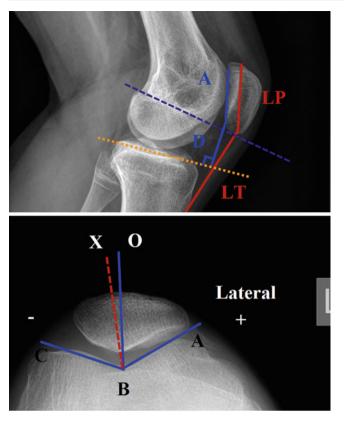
Radiological indices around the knee. Top radiograph (*knee lateral*) shows the Blumensaat's line (*blue dashed*) touches the lower border of the patella. Insall-Salvati index: Ratio, or index, of patella tendon length (LT) to patella length (LP) should be 1.0. An index of 1.2 is alta and 0.8 is baja. Blackburne-Peel index: Ratio of the distance from the tibial plateau to the inferior articular surface of the patella (D) to the length of the articular surface of the patella (A) should be 0.8. An index of 1.0 is alta
